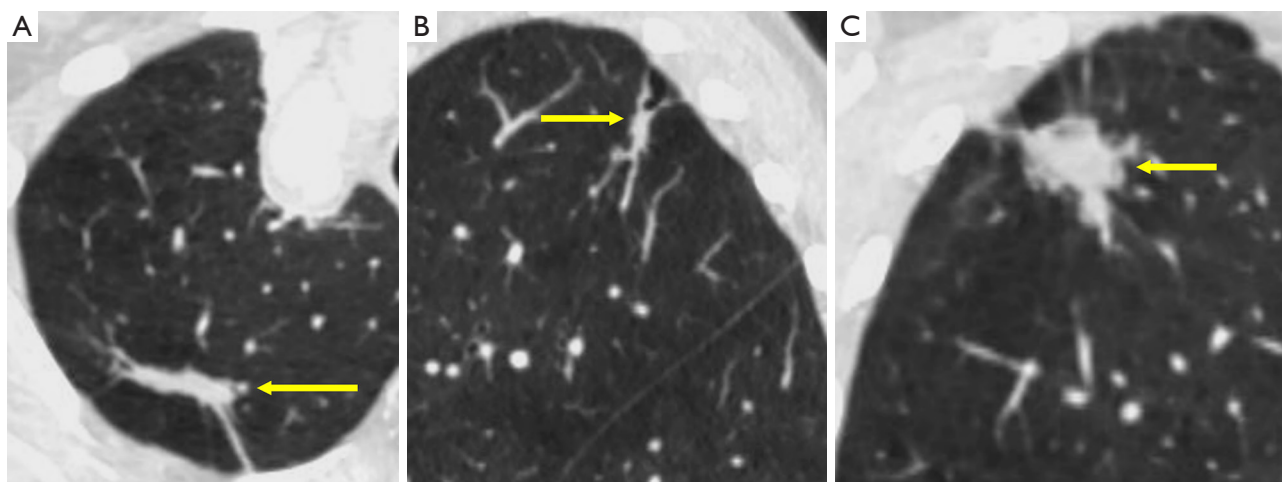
CT images of fibrosis/scar at the right upper lobe. (A) Axial and (B) sagittal reconstruction planes show pleural-based configuration, and elongated shape, straight margins, and presence of similar adjacent opacities are suggestive of a scar (arrow). Note that the fibrosis mimics a spiculated nodule on the coronal plane (arrow) (C). CT, computed tomography.
